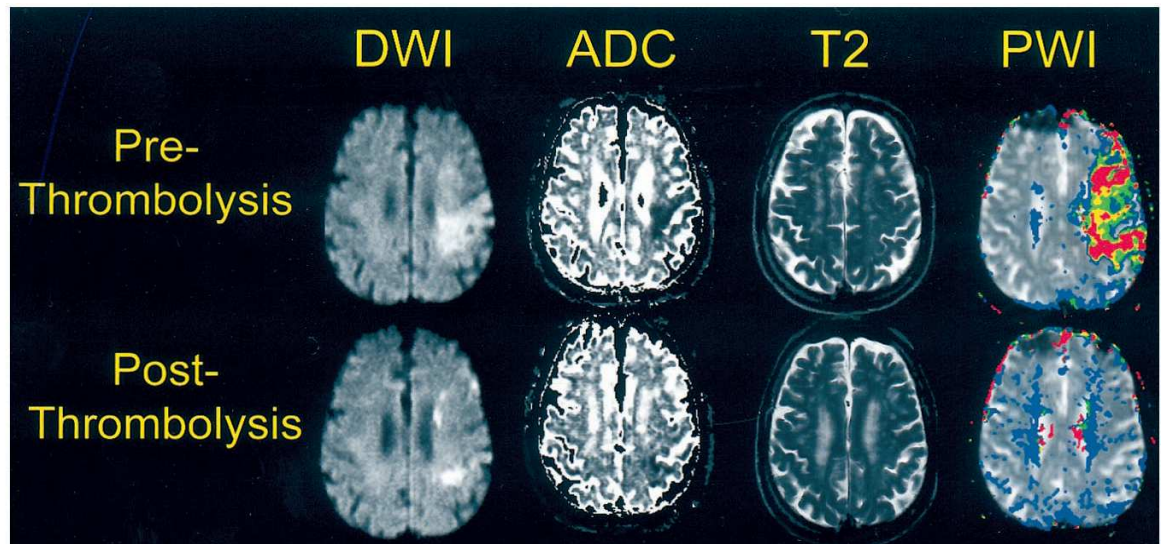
Evidence of reversible DWI-defined lesion in a human stroke patient following thrombolysis. Note the reduction in the DWI-defined lesion post-thrombolysis (Kidwell et al, 2000)
